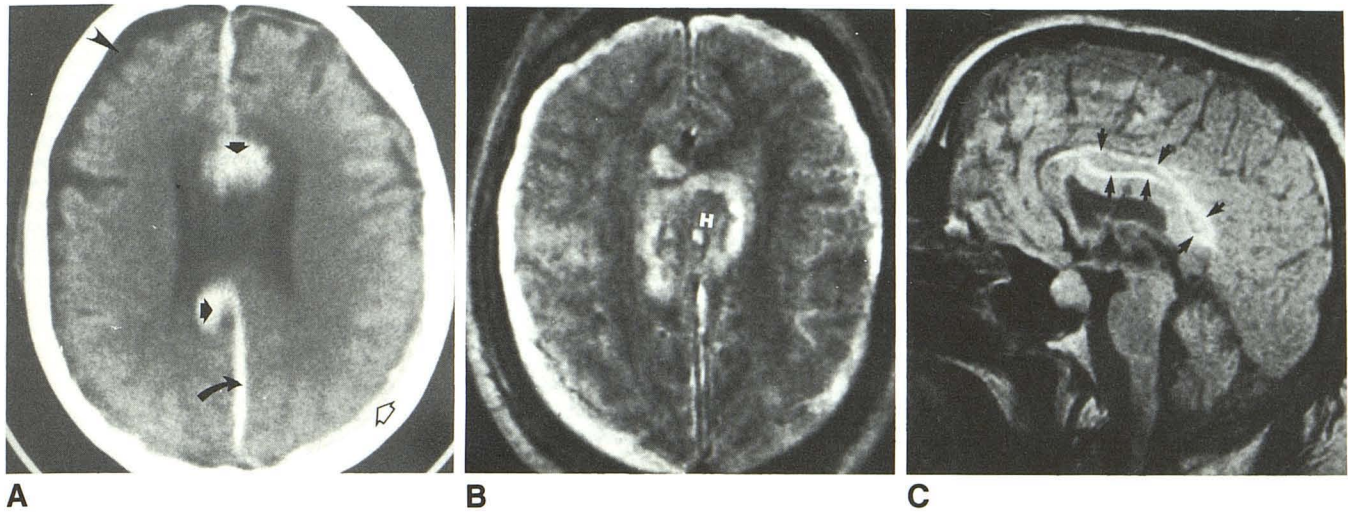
A, Axial CT scan reveals hemorrhagic injury of genu, body, and splenium of corpus callosum (*straight solid arrows*). Also present are acute interhemispheric (*curved arrow*) and convexity (*open arrow*) subdural hematomas as well as chronic right convexity (*arrowhead*) subdural. B, Axial T2-weighted MR image, 2000/120, 5 days after injury. Marked hypointensity of acute callosal hematoma (H) probably is secondary to preferential T2 proton relaxation enhancement due to presence of intracellular methemoglobin/deoxyhemoglobin [42]. Other subdural hematomas are seen also. C, Sagittal T1-weighted image, 1000/30, more clearly reveals extent of hemorrhagic callosal lesion. Small, peripheral rim of signal hyperintensity, due to methemoglobin, is present around margin of 5-day-old hematoma (*arrows*).
